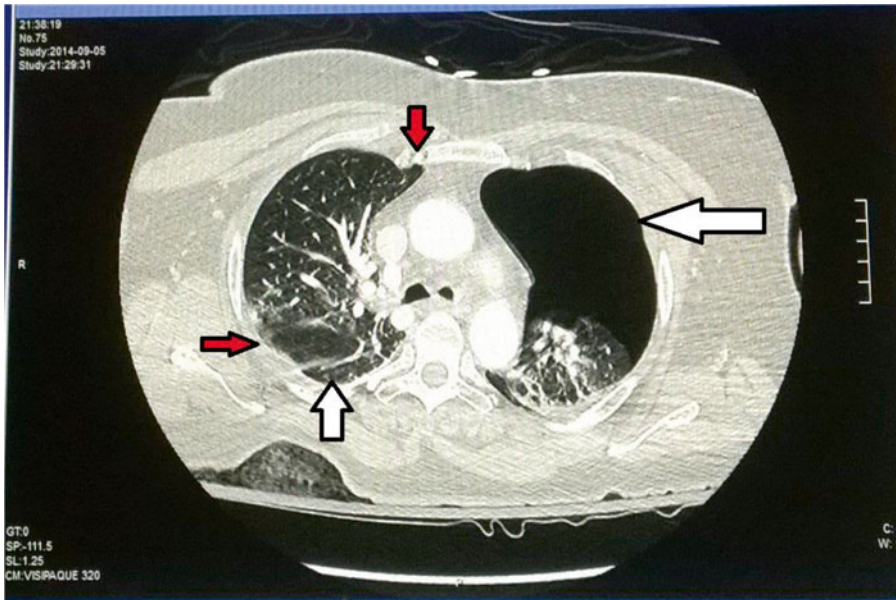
CT thorax: showing a right-sided pneumothorax (*white arrow*), sternal fracture (*downward arrow*), left-sided flail segment (*red-colored sideward arrow*), and contused lung (*upward white arrow*)
